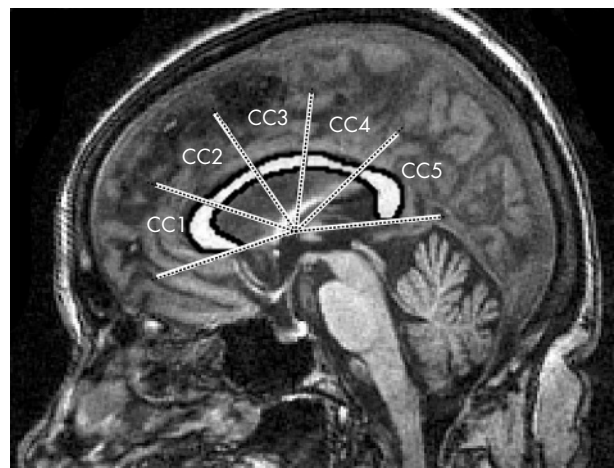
Segmentation of the corpus callosum (CC) subregions from the mid-sagittal magnetic resonance imaging slice. CC1, rostrum and genu; CC2, rostral body; CC3, midbody; CC4, isthmus; and CC5, splenium.
